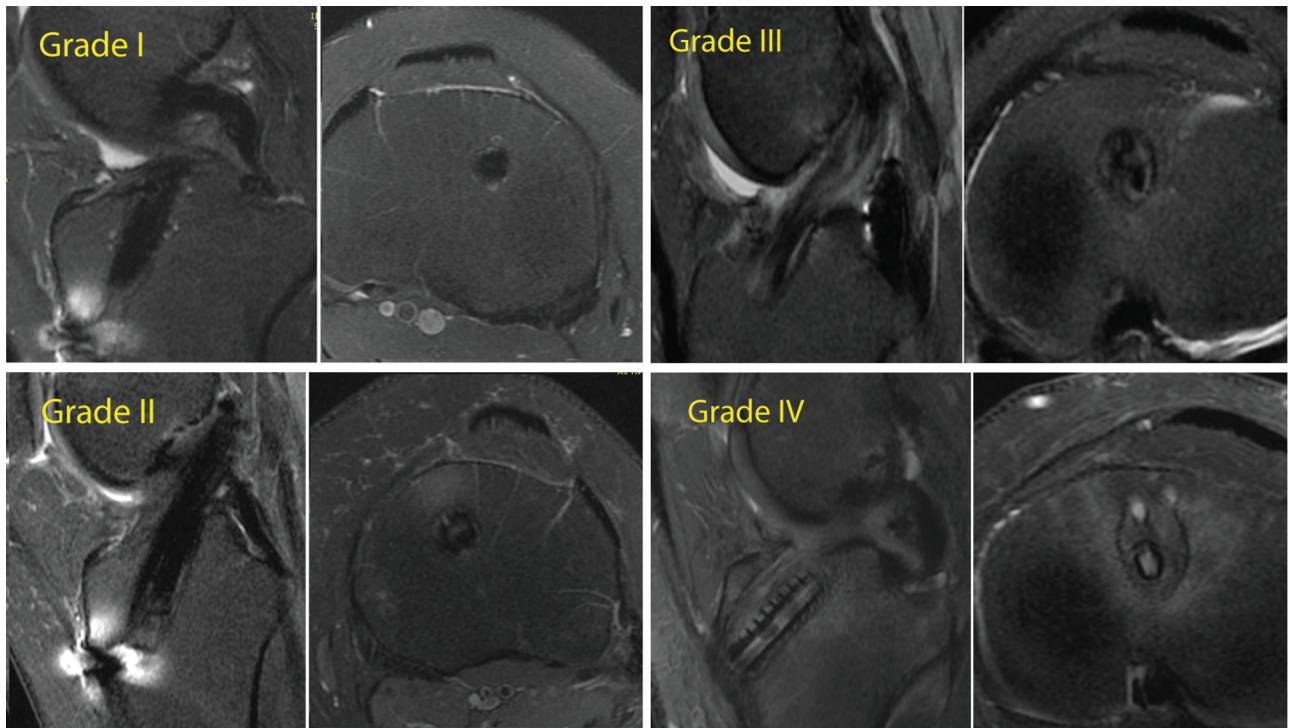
Graft signal examples on magnetic resonance imaging as graded by Howell et al²⁰ (grades I-IV).
